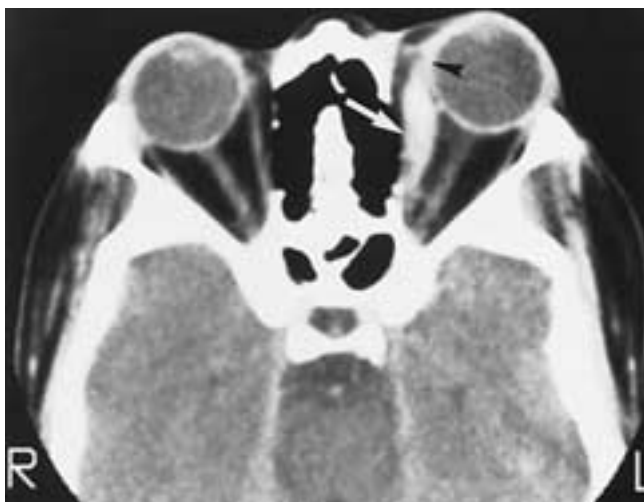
Myositic pseudotumor. Postcontrast Axial CT scan shows marked thickening and enhancement of the left medial rectus muscle (arrow). Note extension of the process into its tendinous insertion on the globe (arrowhead). (From Flanders AE et al. CT characteristics of orbital pseudotumor and other orbital inflammatory processes. *J Comput Assist Tomogr* 1989;13:40–47.)
